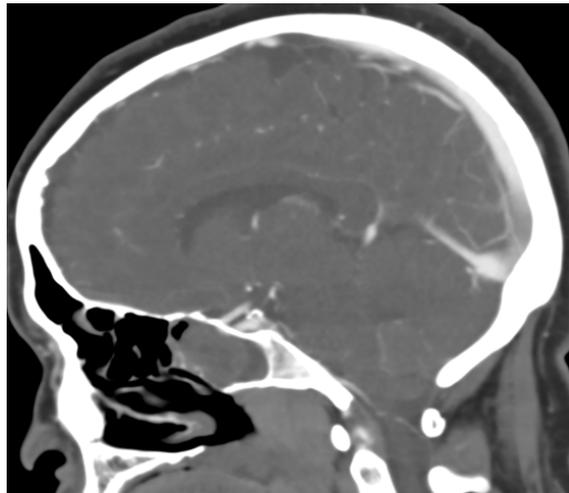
Sagittal contrast-enhanced CT confirming the encephalocele sac extending into the sphenoid sinus, without evidence of associated CSF leak or mass effect on adjacent structures.
